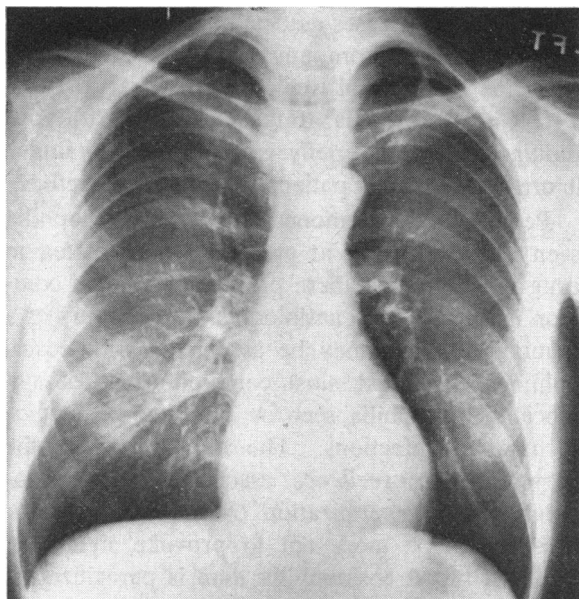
Radiographic film taken in April 1968, showing normal heart size.
